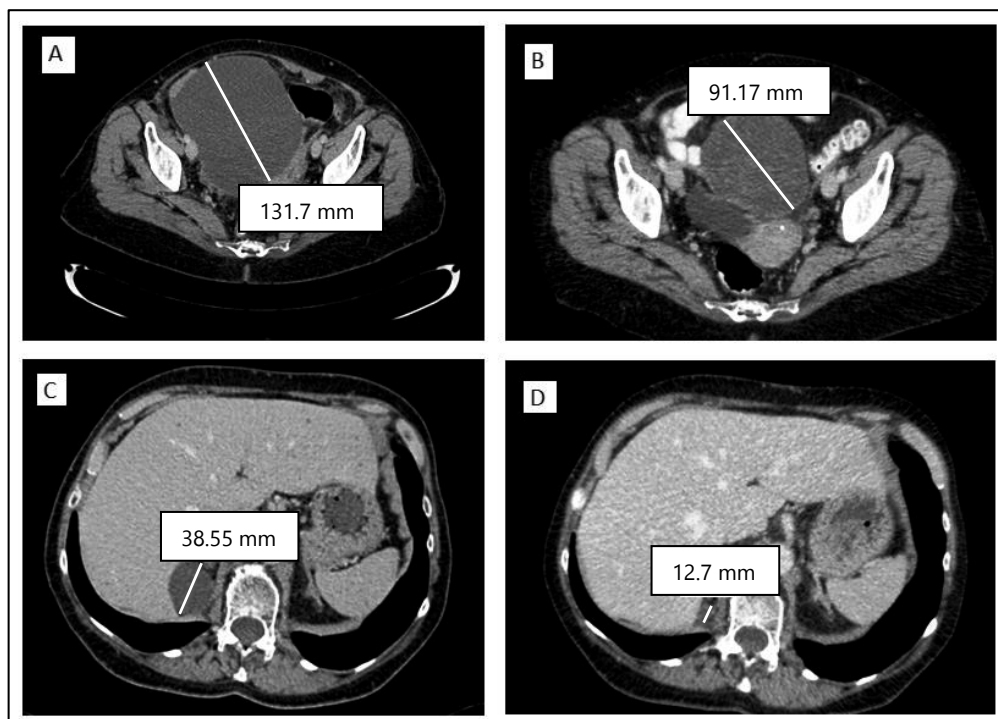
CT scan images of a liposarcoma patient who obtained a PR. Retroperitoneal lesion at baseline (A) and after 24 weeks of treatment (B). Liver lesion at baseline (C) and after 24 weeks of treatment (D).
